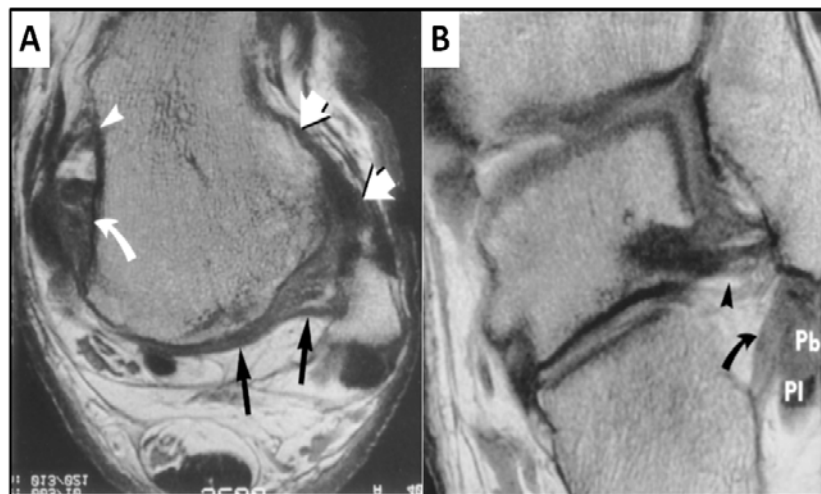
MRI axial imaging showing the anterior talofibular ligament (straight white arrows), the posterior talofibular ligament (PTFL) (black arrows), the anterior tibiotalar ligament (arrowhead) and the posterior tibiotalar ligament (curved arrow); B, MRI coronal imaging showing the calcaneofibular ligament (arrow) and the PTFL (arrowhead) (modified from Muhle et al., 1999).
